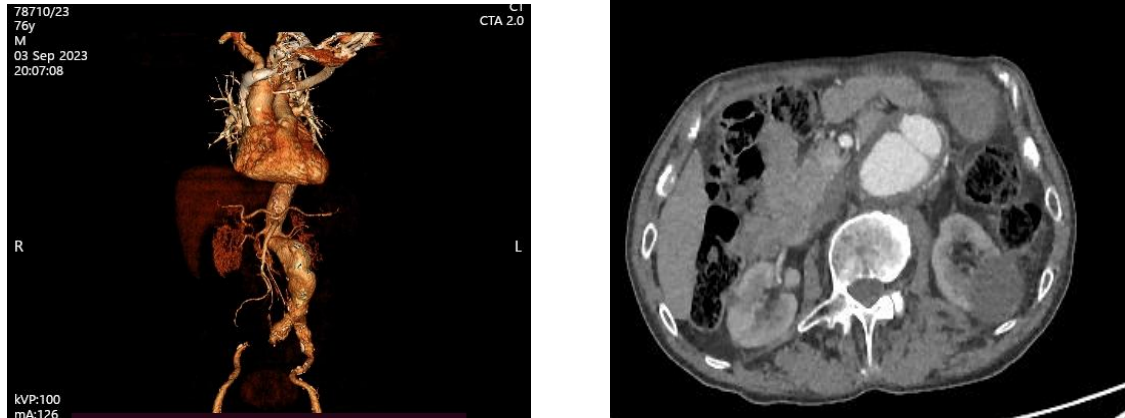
CT angiography showed an infrarenal aortal aneurismatic dilatation with a flap
